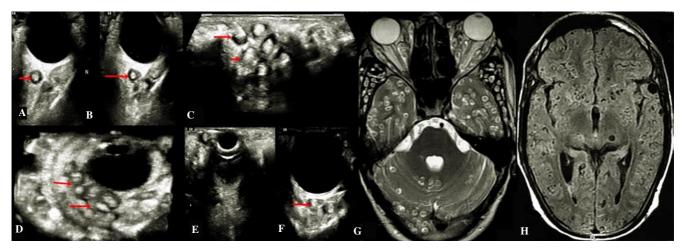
High-resolution sonography of the orbits showing multiple cysts (red arrows) involving the orbits (A-F). MRI brain T2W image shows multiple cystic lesions with scolex suggestive of neurocysticercosis involving the brain and the orbits (G). MRI brain FLAIR sequence shows massive cysticercosis (H).
